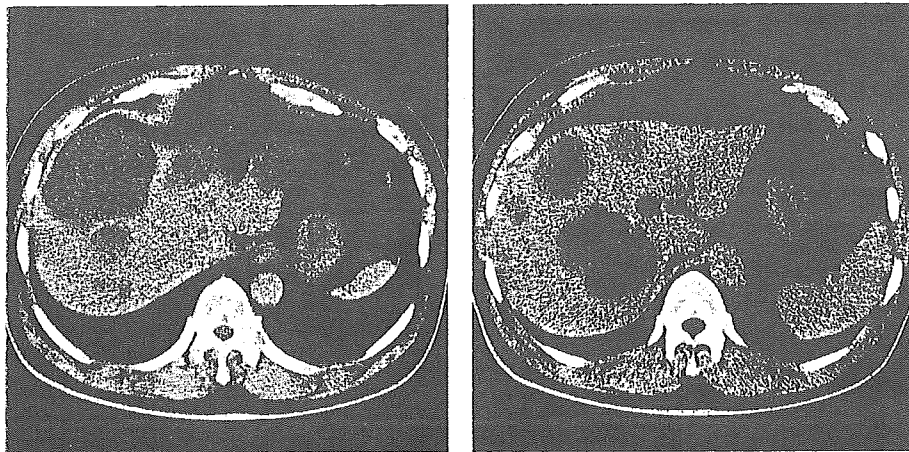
Abdominal CT : Multiple liver cysts and mild liver atrophy are shown.
